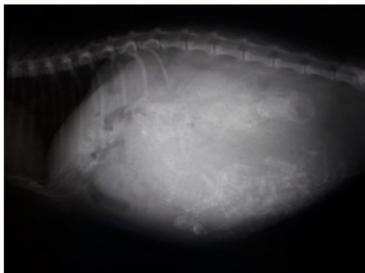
Lateral abdominal x-ray showing fetal skeleton.
